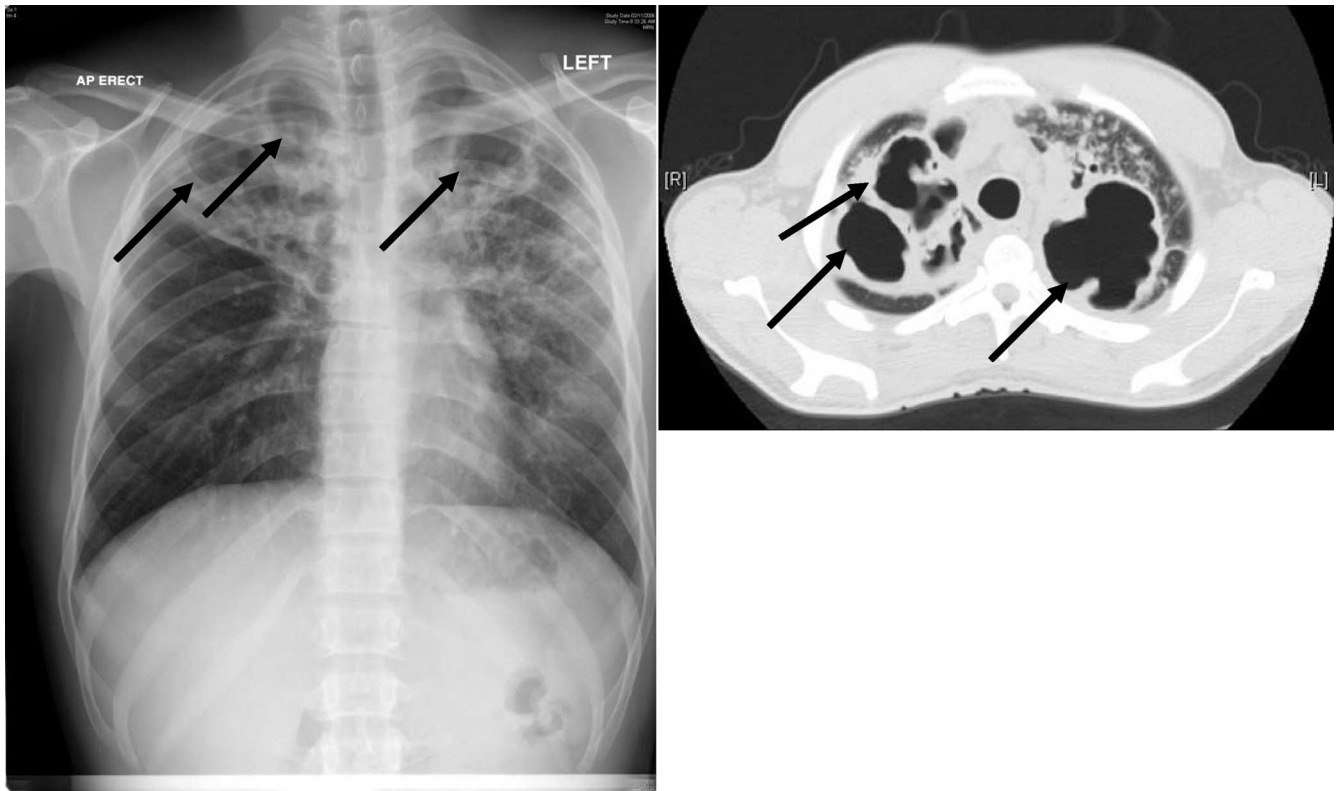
Extensive cavitary lung disease due to *Mycobacterium tuberculosis* visualized by plain chest radiography (left) and computed tomography (right). Note the typical upper lobe predominance and extensive fibronodular infiltrates.
